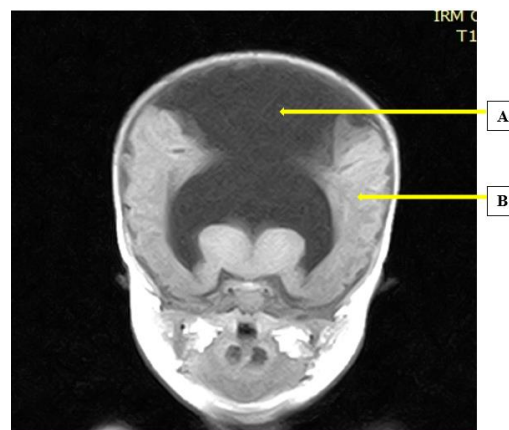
MRI scan of the encephalon in frontal section displaying a single dilated cavity giving the rest of the parenchyma a horseshoe appearance. A= Single dilated cavity, B= Remaining cerebral parenchyma.
